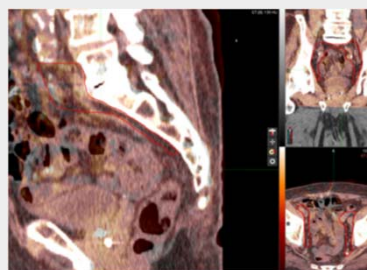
The PLN structure (red) was copied from CT to CBCT when the bony structure was aligned.
